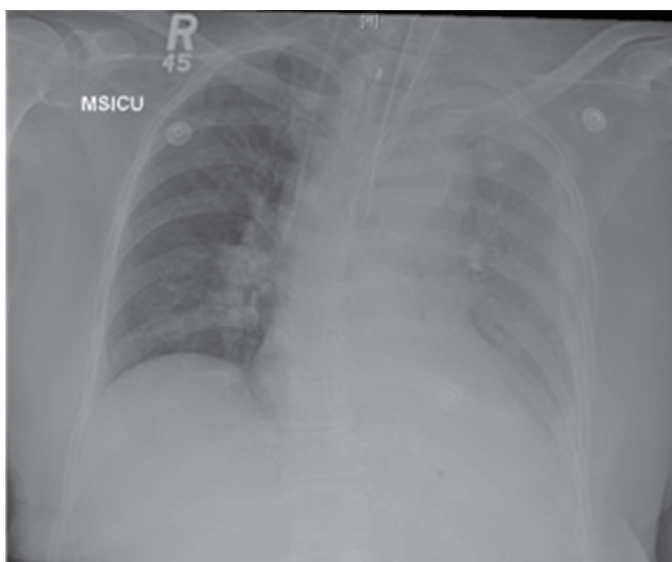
Chest X-ray showing left side pleural effusion.
